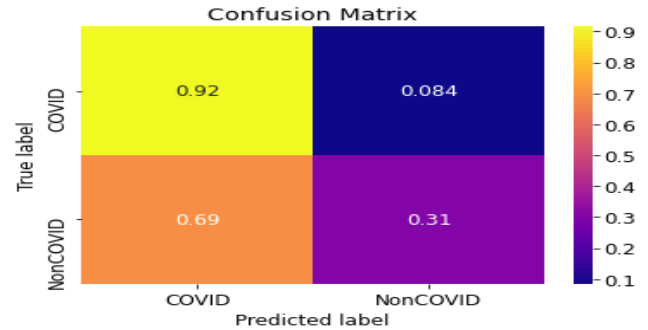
Confusion Matrix of RESNET model for X-Ray images
